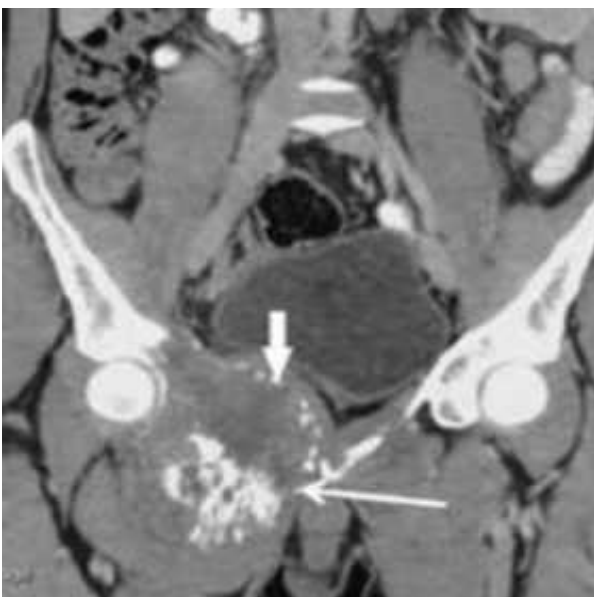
Coronal plan CT image of the mass with heterogeneous density.
